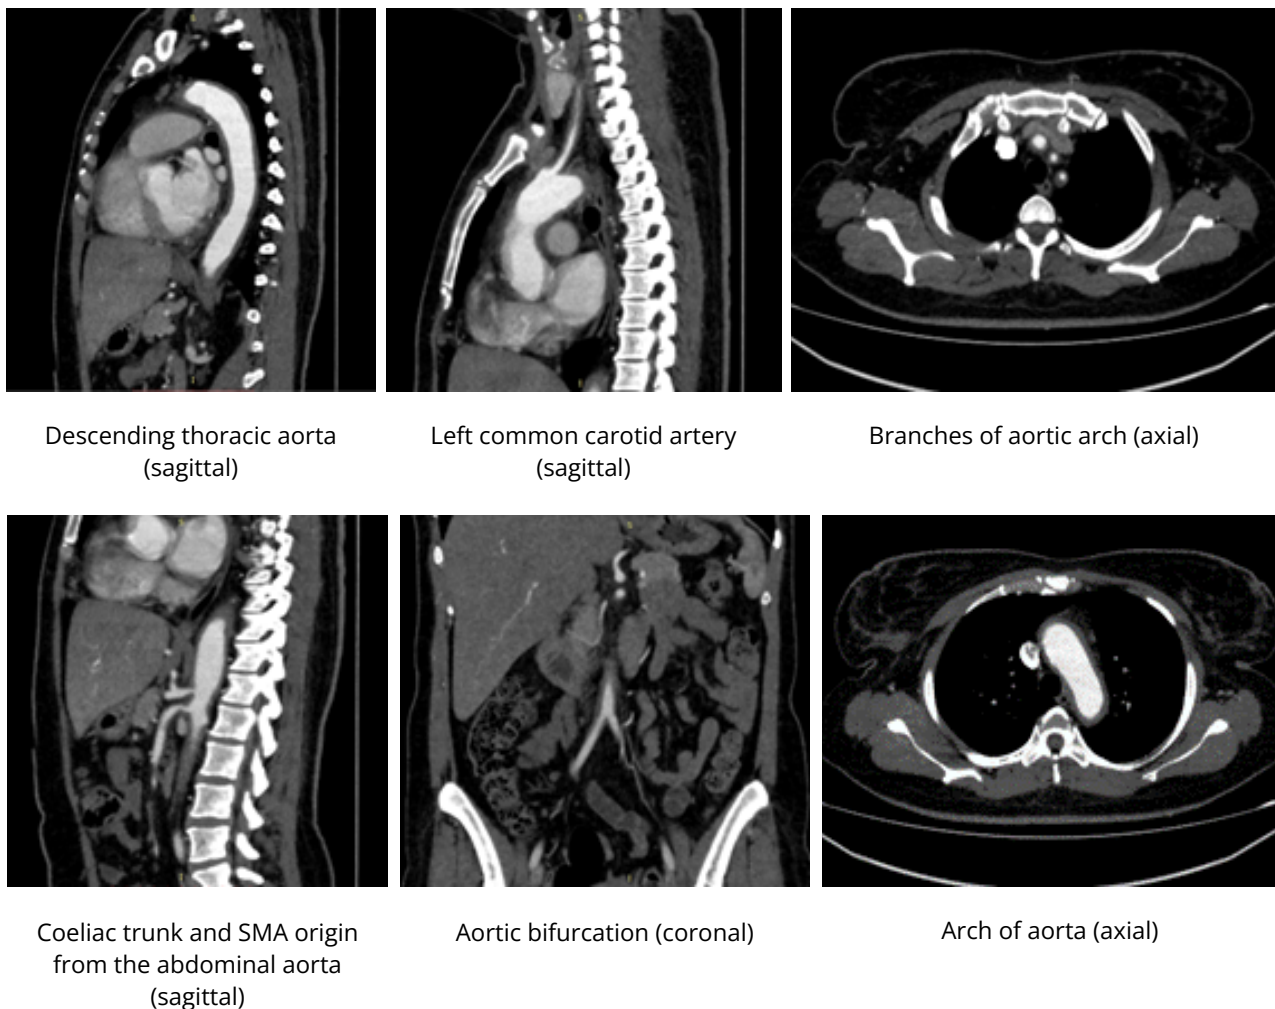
CT aortogram demonstrating luminal wall thickening
